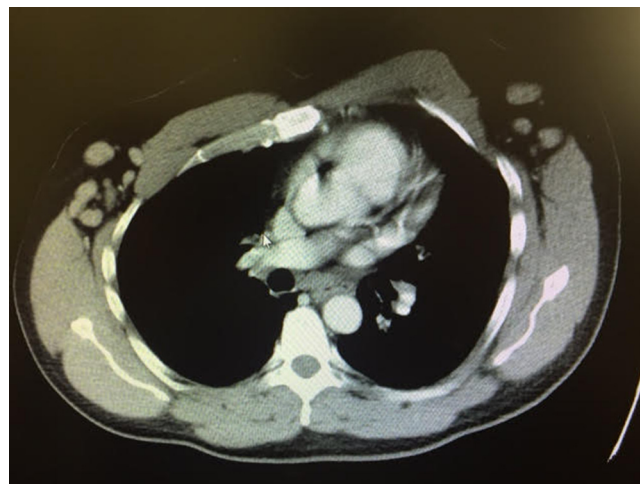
Chest CT axial view with bilateral axillary lymphadenopathy in the setting of splenomegaly.
